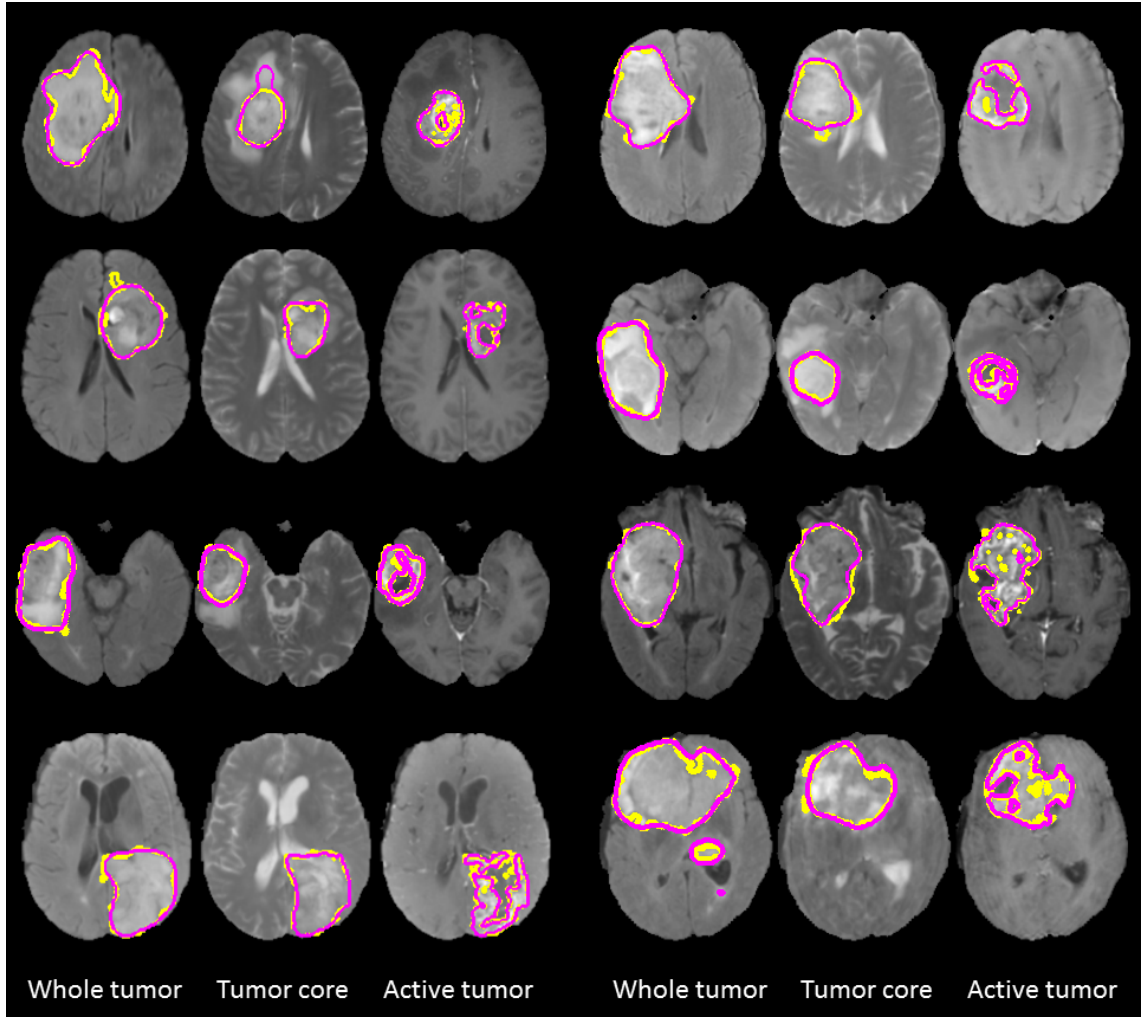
Example of consensus expert annotation (yellow) and automatic segmentation (magenta) applied to the test image data set. Each row shows two cases. From left to right: segmentation of whole tumor (shown in FLAIR), tumor core (shown in T2) and active tumor (shown in T1c).
